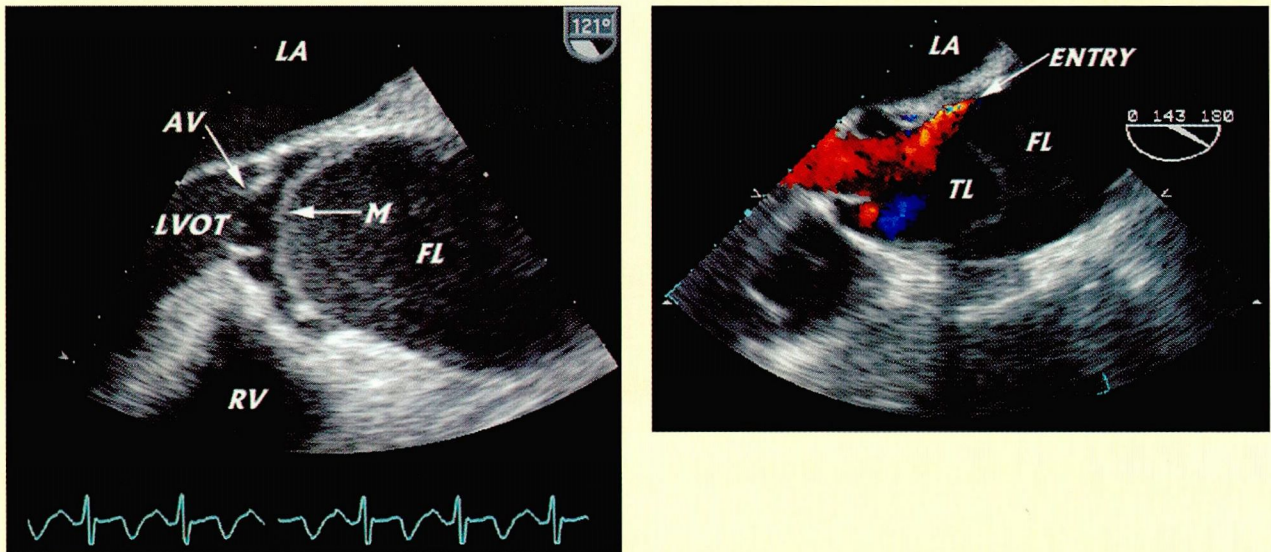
Acute dissection of the ascending aorta (DeBakey type I, Stanford type A), long-axis views. Left, the dissection membrane (M) is seen in the aortic root, and most of the ascending aorta is occupied by the false lumen (FL). The ascending aorta is dilated (diameter, 5 cm). AV—aortic valve, LA—left atrium, LVOT—left ventricular outflow tract, RV—right ventricle. Right, color Doppler flow mapping in a different patient during systole. Note the open aortic valve. TL—true lumen.
